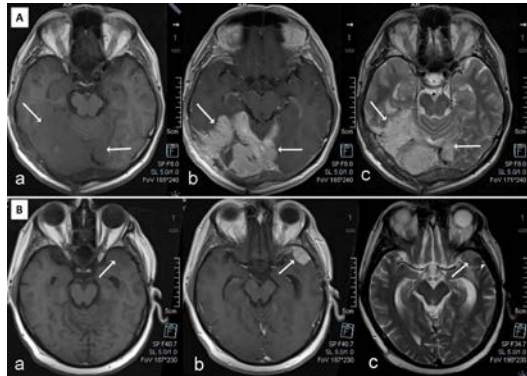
A: Axial T1-weighted MR image of Case 1
